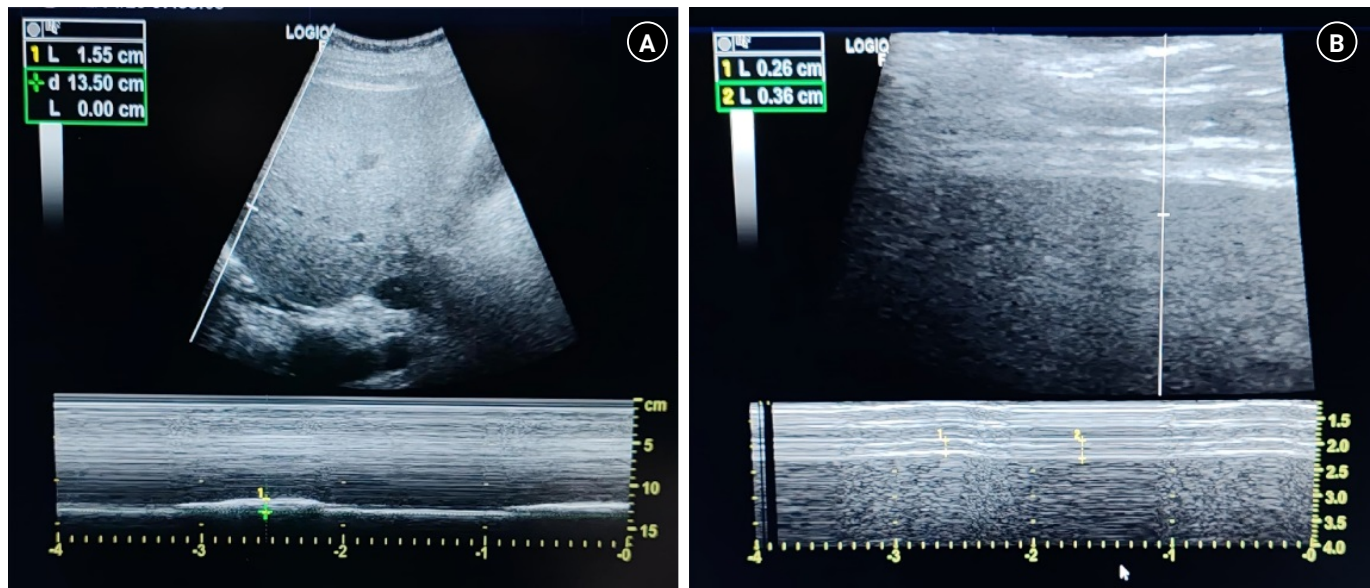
Ultrasound assessment of diaphragmatic function. (A) Diaphragmatic excursion measurement, showing a 1.55-cm displacement during spontaneous breathing. (B) Diaphragm thickening fraction (DTF) measurement, showing end-expiratory thickness (0.26 cm) and end-inspiratory thickness (0.36 cm) yielding a DTF of 38%.
